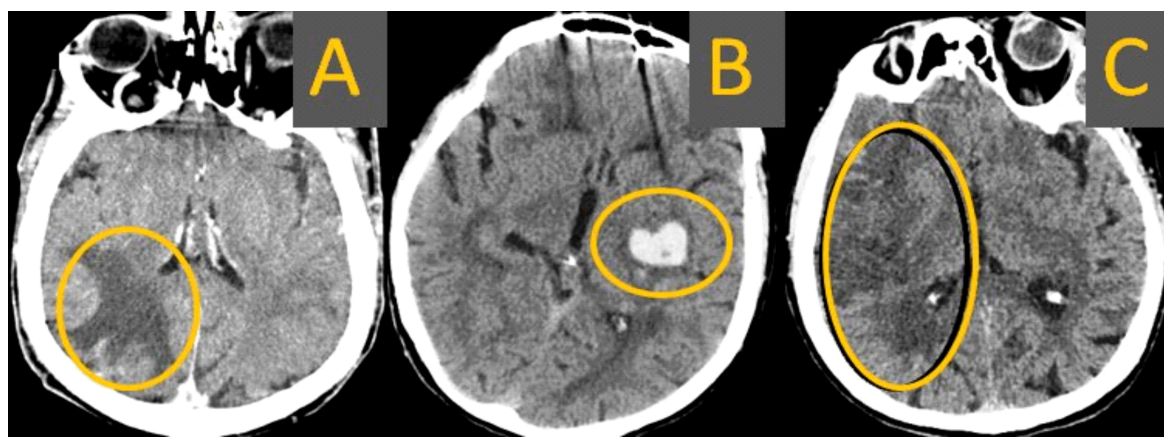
CT examination in the case of ischemic stroke, hemorrhagic stroke and ischemic stroke with hemorrhagic transformation: (A) Ischemic right parieto-occipital edema without contrast uptake and without medial line mass effect – ischemic stroke right PCA, right lateral homonymous hemianopsia (occipital lobe) with light right hemiparesis (subthalamic area) and right hemihypoesthesia (parietal lobe); (B) Native CT, hyperdense hemorrhagic lesion in left interior capsule; (C) Native CT, hypodense area in the territory of the right MCA with minimal hemorrhagic transformation. CT: Computed tomography; PCA: Posterior cerebral artery; MCA: Middle cerebral artery.
